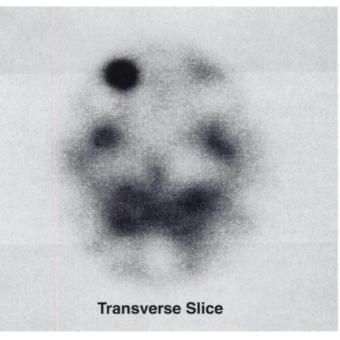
SPECT image (transverse slice at the level of the orbitae) obtained in a patient with ocular melanoma of the right eye. Intense and homogeneous tracer fixation is seen in the pathological eye. Pathological-to-normal eye ratio 2.8.
